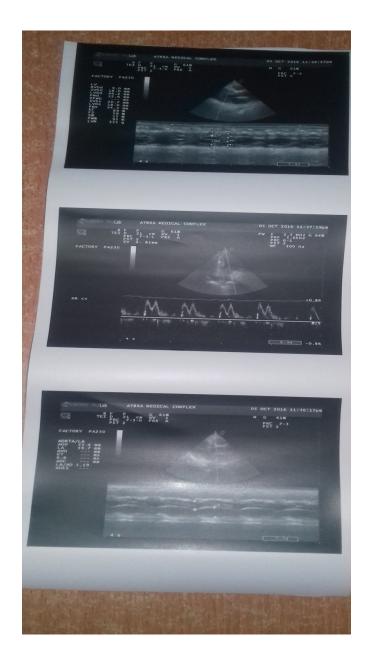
Image NO(3) 53 years old female, LAX, and apical 4chamber view showing LVH and diastolic dysfunction.
